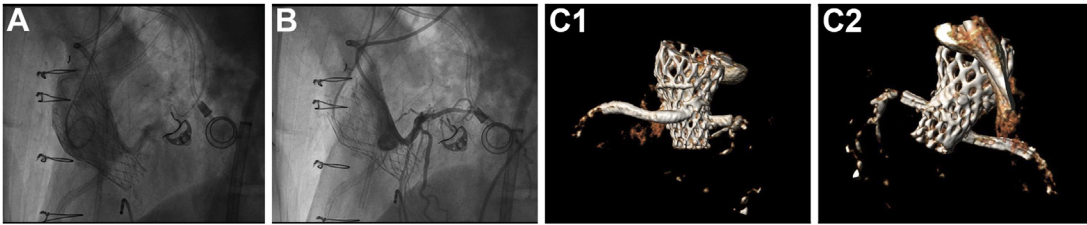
TAVI with double chimney technique result. (A) Aortic angiography showing good valve position without aortic regurgitation and perfect coronary patency. (B) Selective LM injection. (C) 3D CT scan reconstruction showing the relation between the valve and both chimney stents in RCA (C1) and LM (C2).
